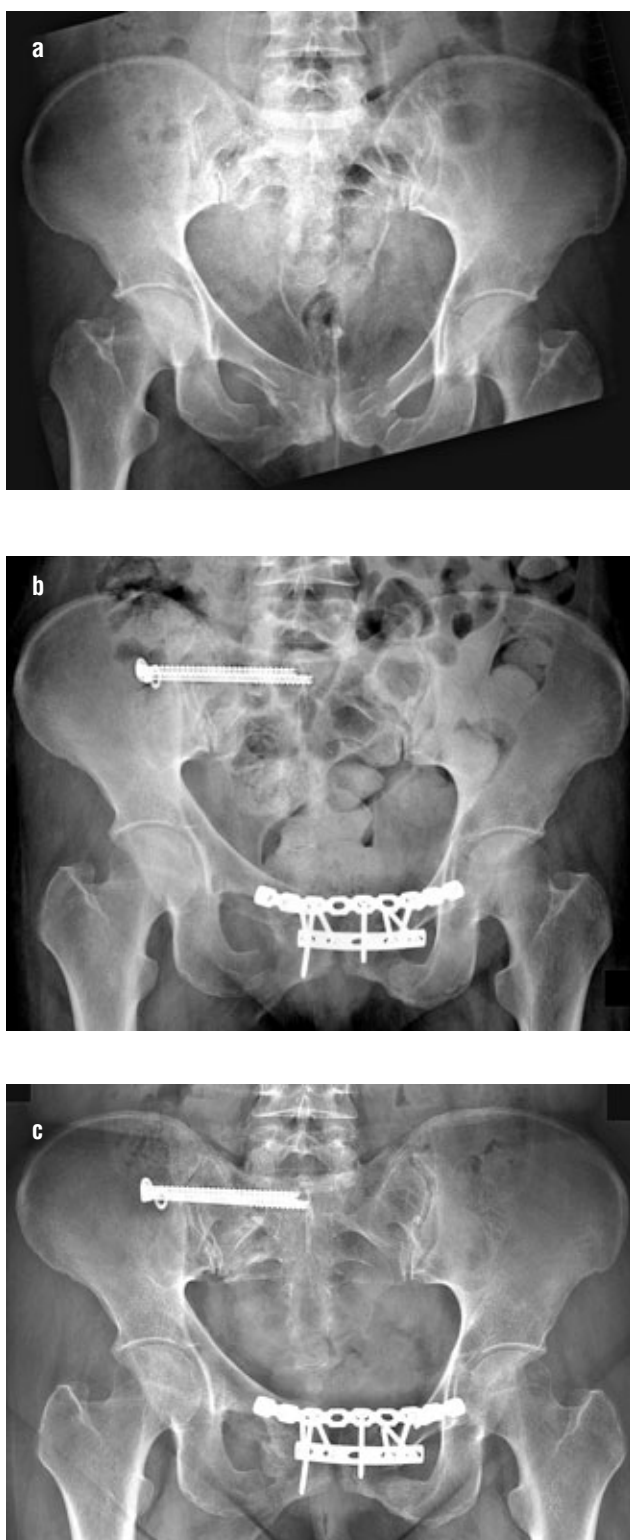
X-ray documentation of a 47-year-old woman with a type C1.3 pelvic fracture occurring after a traffic accident: a – fracture of the lateral part of the sacrum on the right and bilateral fracture of the pubic rami with proximalisation of the right hemi-pelvis by 1 cm; b – follow-up X-ray 6 weeks after fixation with migration of one screw by 3 mm; c – follow-up X-ray at three months with screw migration by 5 mm (at this time the patient did not have any pain and there were radiological signs of fracture healing).
